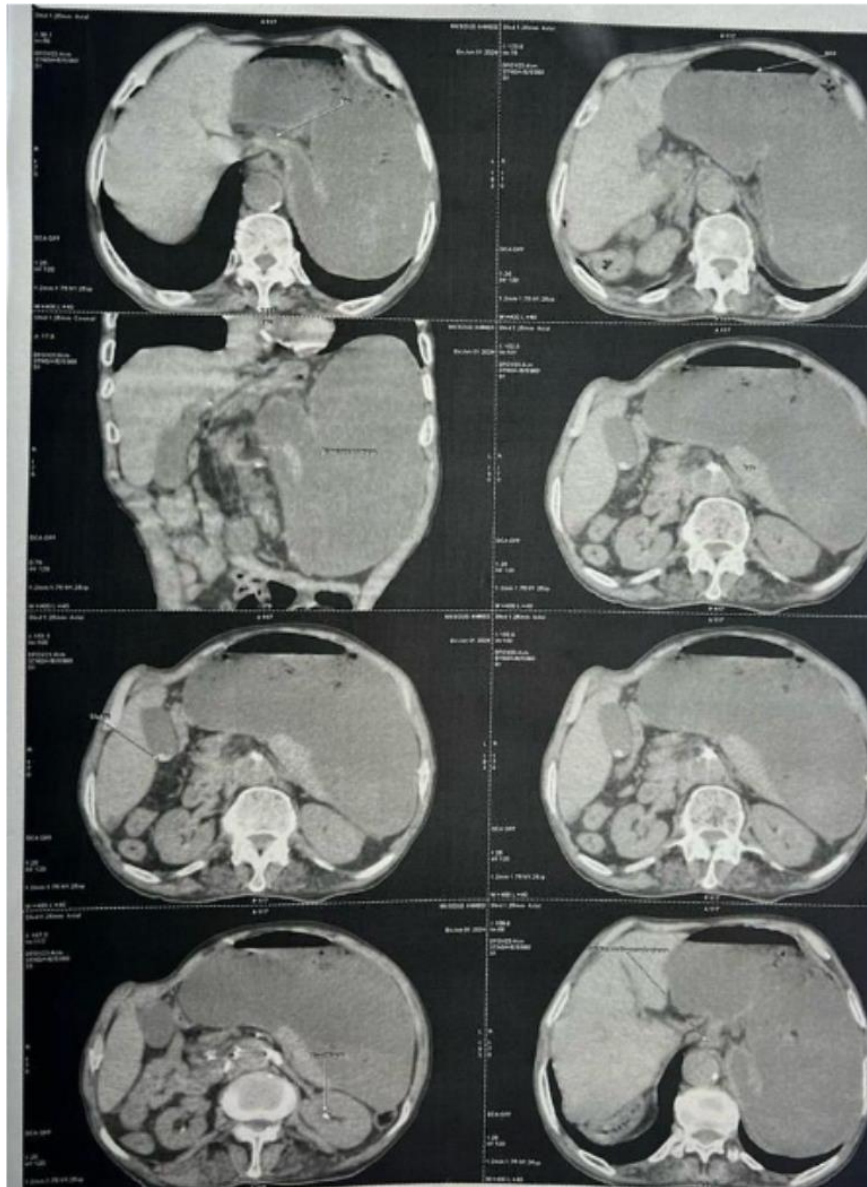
CT SCAN images.
